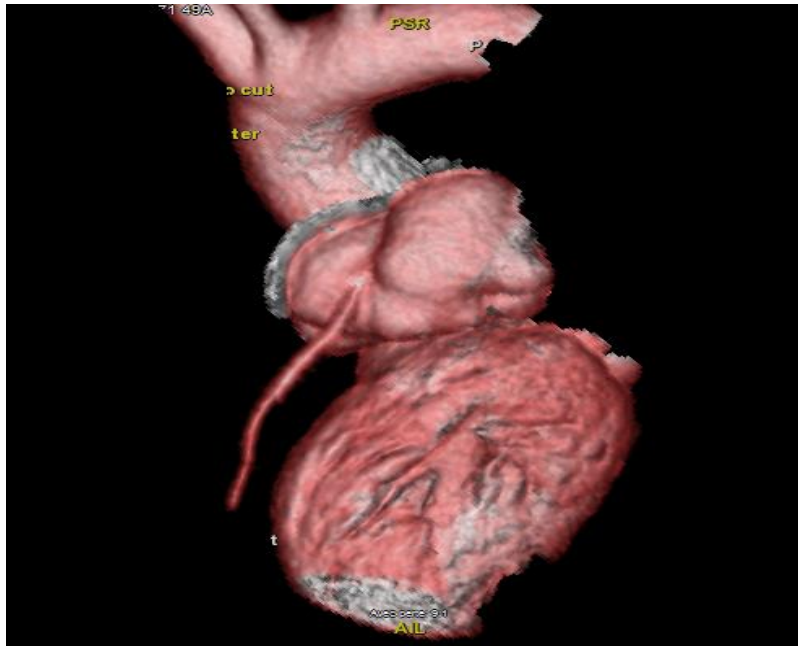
Thoracic CT scan reconstruct in 3D: a LVOT pseudoaneurysm compresses LAD artery
